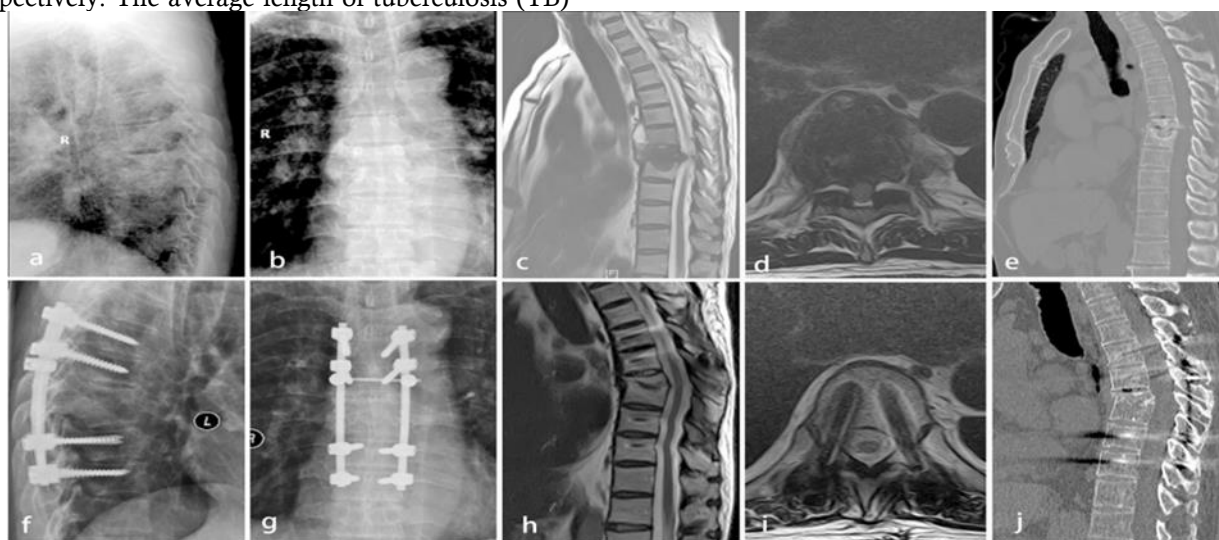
A posterior-only debridement, autogenous iliac bone transplant, internal fusion, and instrumentation are used to treat a 73-year-old male patient with thoracic tuberculosis (TB) (T7-8). The anterior and middle columns of T7-8 were destroyed, and a lesion surrounding the vertebral body of T7 had an abscess with significant bone damage, as revealed by preoperative radiography (a and b), MRI (c and d), and CT (e). At the last follow-up, radiography (f and g) demonstrated the successful completion of definitive bone fusion. The epidural abscess was completely resolved on postoperative MRI (h and i) and CT (j), and the neural component was decompressed.
